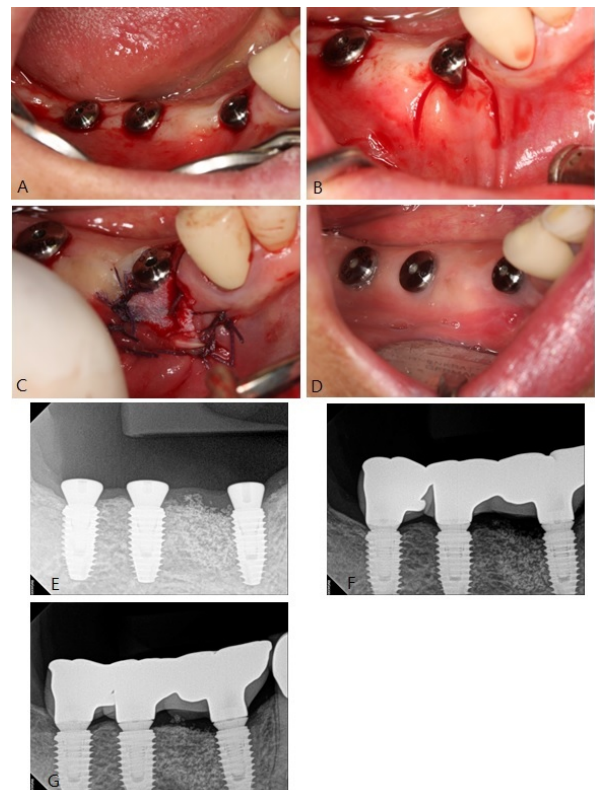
Procedure to create a keratinized mucosa around the implant abutment. (A) Lack of keratinized gingiva; small amount of white portion. (B) Sulcular and bilateral releasing incisions were made. A partial-thickness flap was elevated for an apically positioned flap. (C) Megaderm application. (D) Appearance at 2.5 months after implant placement. (E) Periapical radiograph after second surgery. (F) Periapical radiograph 5 months after prosthetic loading. (G) Periapical radiograph 1 year after prosthetic loading.
